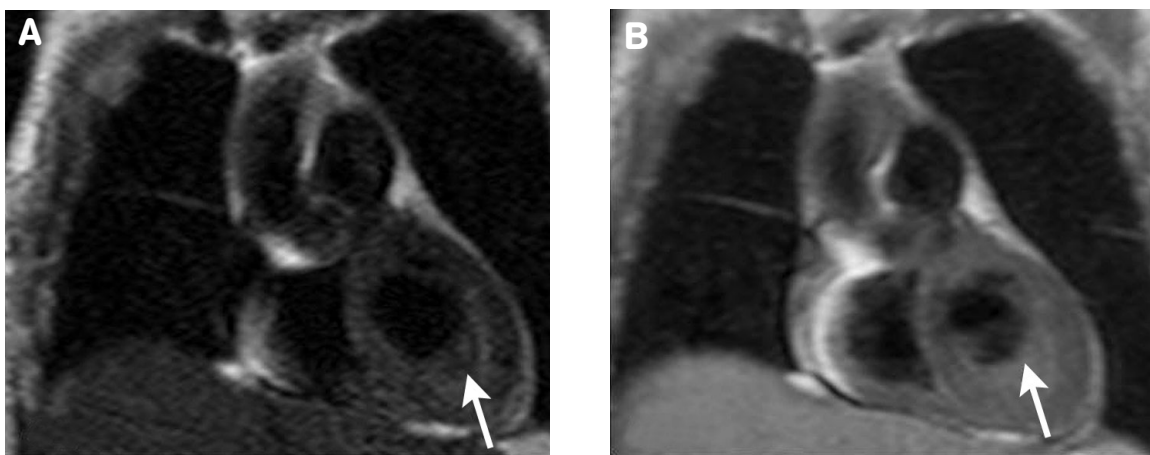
Cardiac MRI reveals one intraventricular mass-like lesion ($2.7 \times 2.3 \text{ cm}^2$) in the left ventricle apical region with slight hypointensity on T2WI (A, arrow) and hyperintensity on T1WI (B, arrow).
